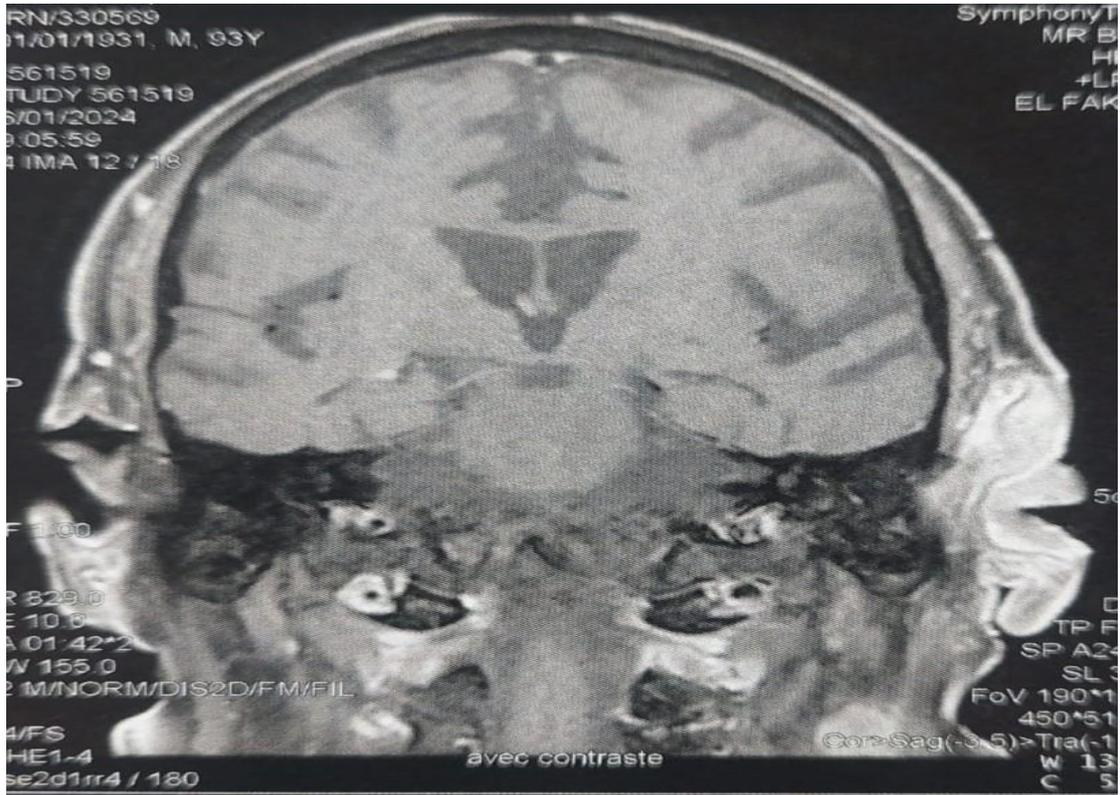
Coronal T2 MRI sequence showing filling of the left external auditory canal with isosignal.
